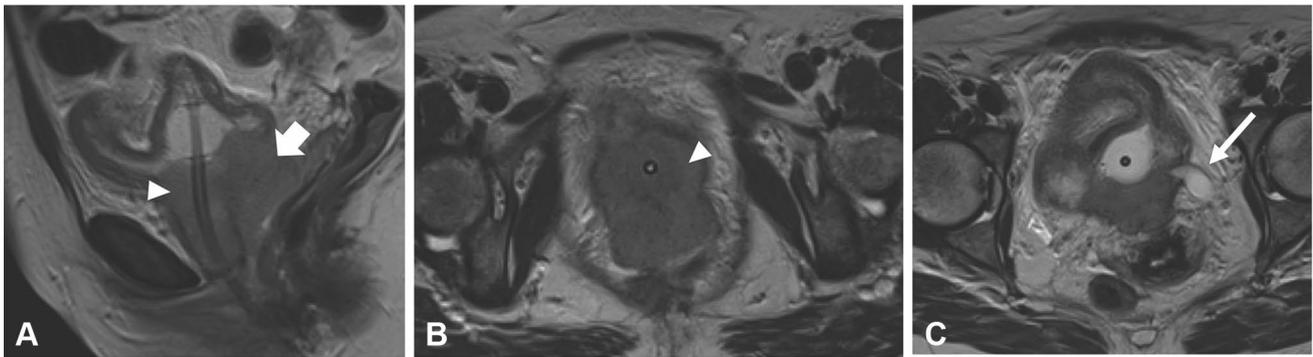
Extensive squamous cell carcinoma of the urethra invading the vagina and bladder. Sagittal (a) and axial (b, c) T2-weighted images of the pelvis show intermediate signal tumor (arrowheads) invading
